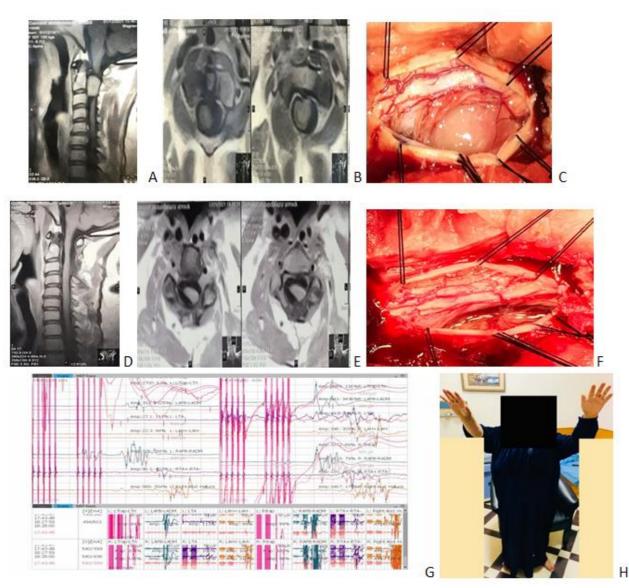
(A, B) sagittal and axial MRI of cervical spine with contrast shows well defined homogenously enhanced lesion AT the level of cervical C2,3 located anterolaterally at right side pushing the cord posteriorly and to the left, (C, F) shows intraoperative durotomy and tumor before and after gross total resection, (G) intraoperative neurophysiological monitoring shows improvement of motor evoked potential (MEP) waves after resection of tumer, (D,E,H) shows fellow up after 3 months pattient completely improved and MRI with contrast showed no signs of residual tumor or recurrence.
